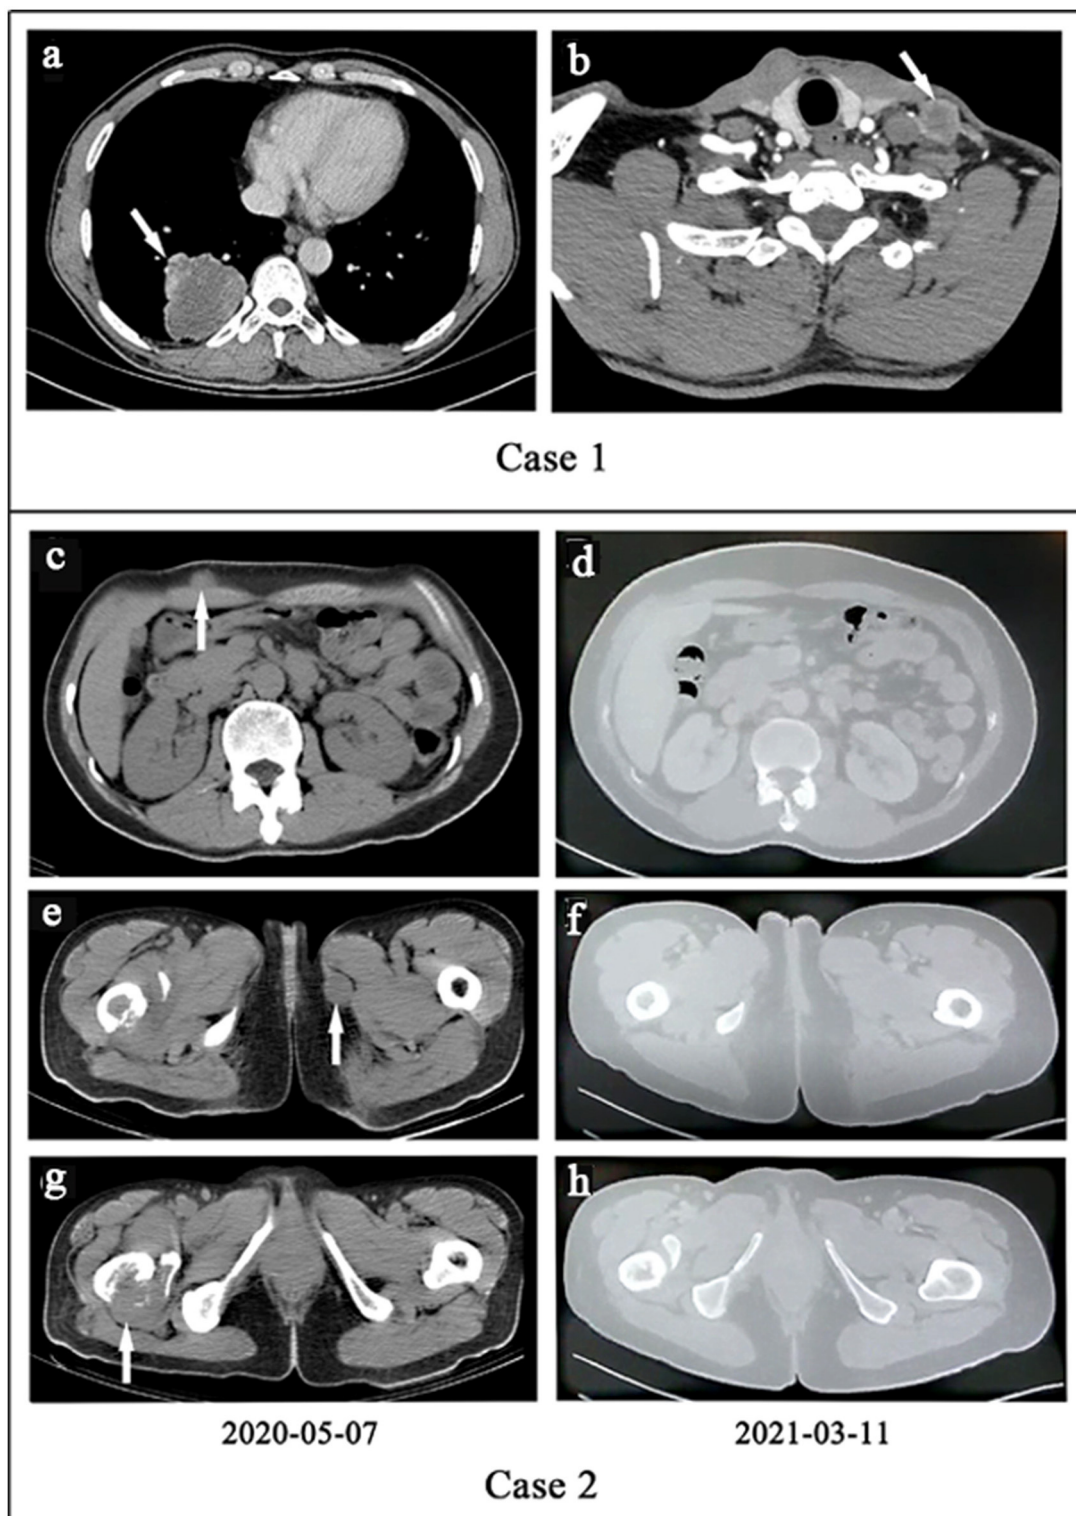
(a,b) Case 1. (a) The computed tomography (CT) of primary lesion revealed a large, irregular mass with a non-uniform density shadow attached to the lower lobe of the right lung. (b) The CT of metastatic lesion showed an uneven density lesion within subcutaneous of the left neck with an unclear border. (c–h). Case 2. Treatment efficacy with Alectinib in Case 2 based on CT scans. (c,e,g) Before Alectinib treatment. Multiple low-density nodules were observed in subcutaneous of the right upper abdomen, the inner side of the left thigh, and the right femur. (d,f,h) Ten months after Alectinib treatment, multiple soft tissue density nodules decreased or disappeared.
